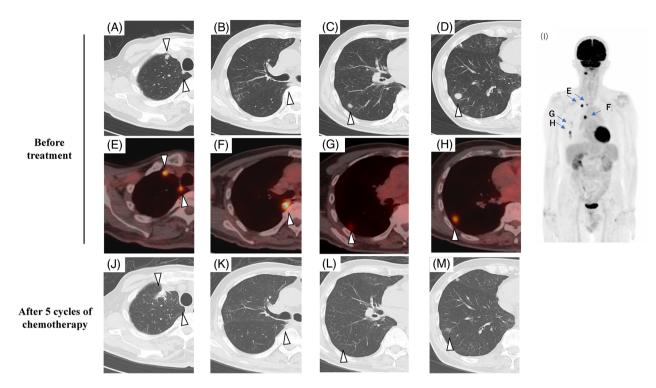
Computed tomography (CT) findings showed multiple pulmonary nodules in the right lung (white arrows) (A–D). 18F-labelled fluorodeoxyglucose (FDG) positron emission tomography (PET) revealed an abnormal accumulation of FDG in the multiple nodules in the right lung (white arrows) (E–H). The coronal image of whole-body PET revealed an abnormal accumulation of FDG in multiple nodules, and no abnormal accumulation of FDG in the hilar/mediastinal and superficial lymph nodes was observed (I). Chest CT findings after five cycles of chemotherapy showed a nodular shadow in the apex of the right lung as postoperative changes, and the other nodules had reduced or disappeared (J–M)
